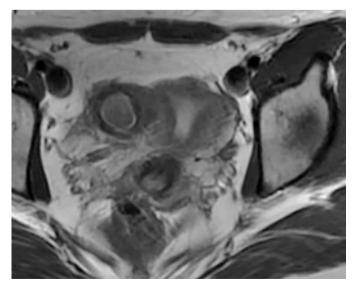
MRI of ACUM in the right lateral myometrium. MRI: Magnetic resonance imaging, ACUM: Accessory cavitated uterine malformation.
